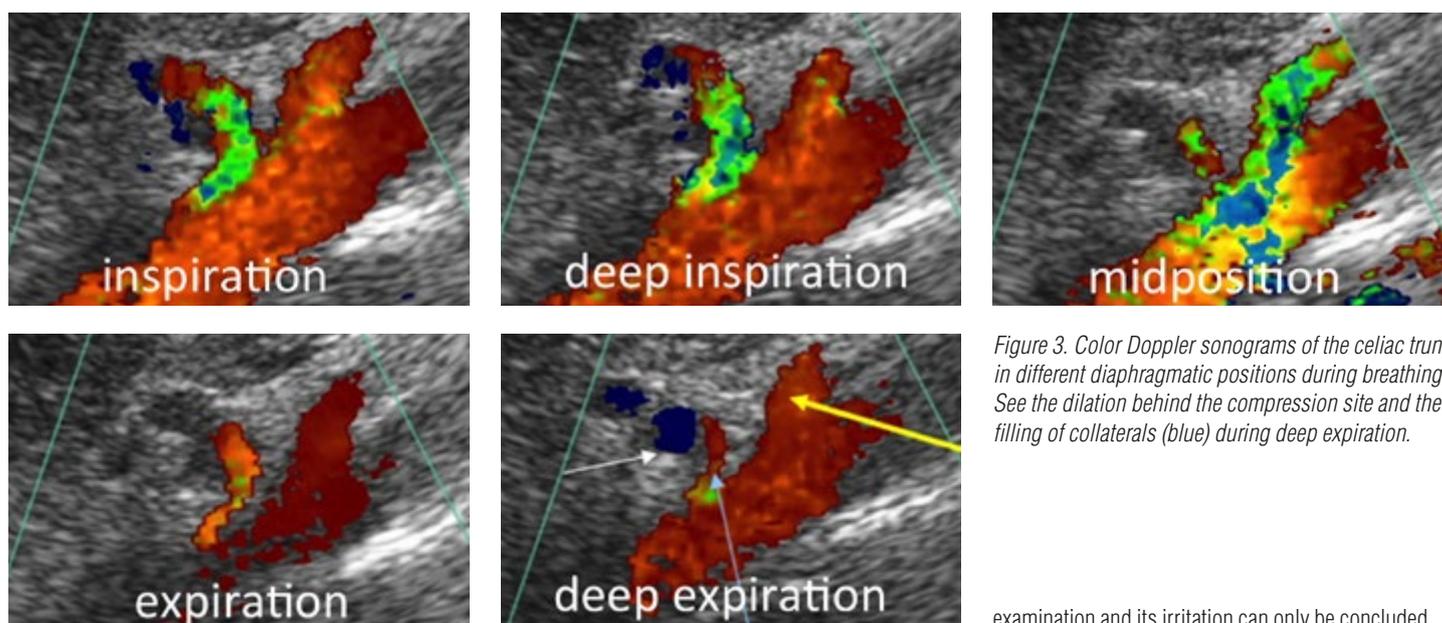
Color Doppler sonograms of the celiac trunk in different diaphragmatic positions during breathing. See the dilation behind the compression site and the filling of collaterals (blue) during deep expiration.
